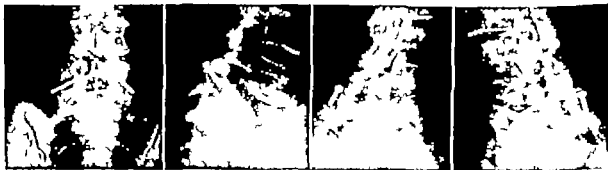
Case 2. Roentgenograms taken one year after operation. a, Anteroposterior arrow marks site of laminectomy. First two films are left and right oblique
